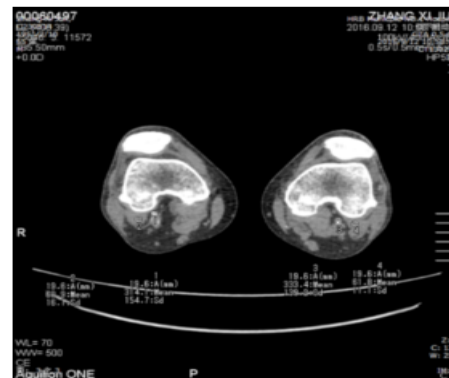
patient’s lower limb arterial examination imaging by 320-slice spiral CT.
